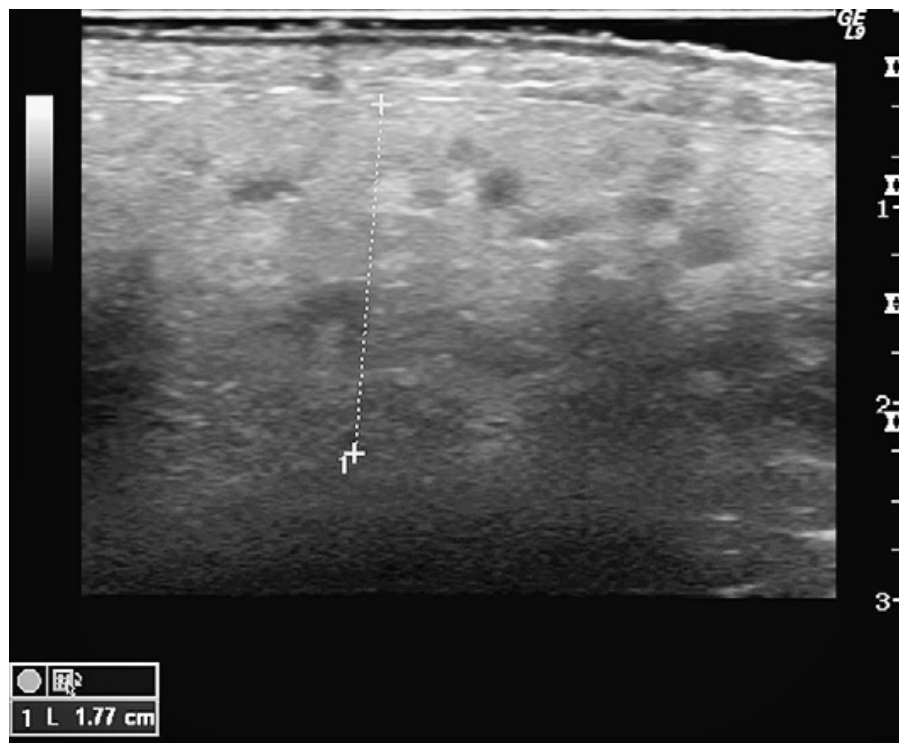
Longitudinal sonogram of left parotid on an adult. Heteroechogenic structure with small hypoechoic nodules. Chronic parotiditis. (Philips Katz et al.)
